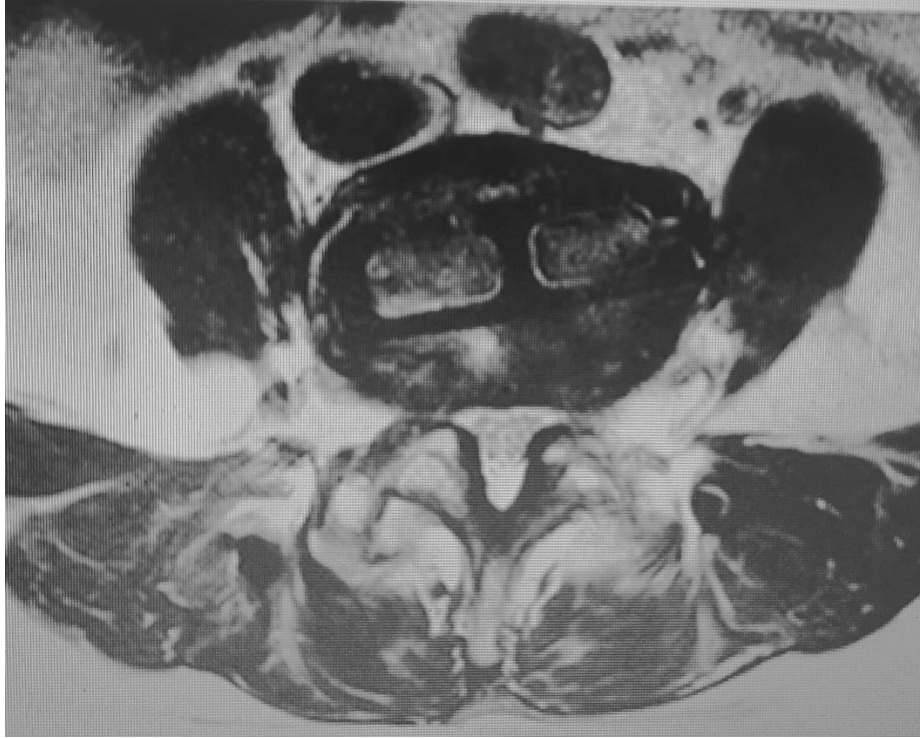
Axial T2 weighted image MRI scan of lumbar spine for female 38 year's old, show Spondylolysis at L4-L5
